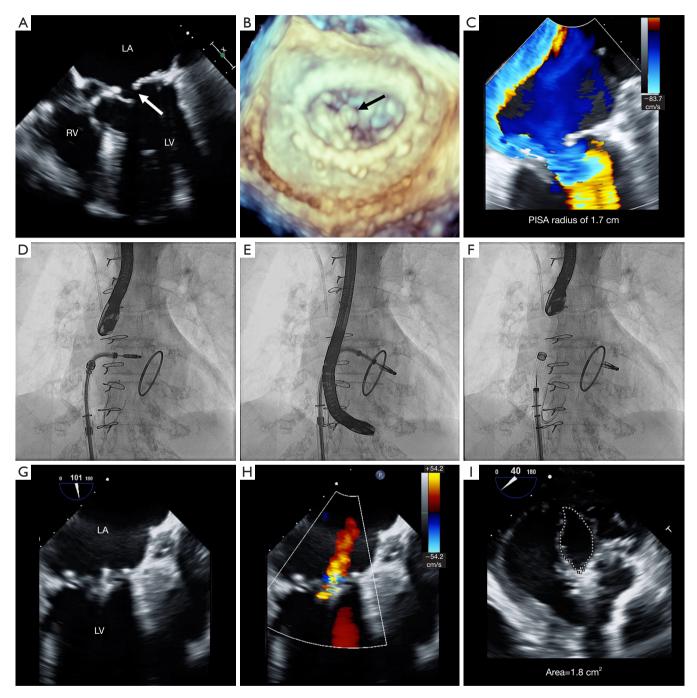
Clinical case of MitraClip after failure of previous surgical repair with annuloplasty. (A) Severe mitral regurgitation; a mid (P2 towards P1) portion of the posterior mitral leaflet is flail due to ruptured chordae, with a flail gap that measures 6 mm (white arrow); (B) three-dimensional transesophageal echocardiography showed flail posterior leaflet (black arrow); (C) severe mitral regurgitation with a PISA radius of 1.7 cm; (D,E,F) transcatheter mitral valve repair (fluoroscopy); (G,H) after the MitraClip implantation, mitral regurgitation reduced to mild; (I) mitral valve area post-MitraClip of 1.8 cm².
